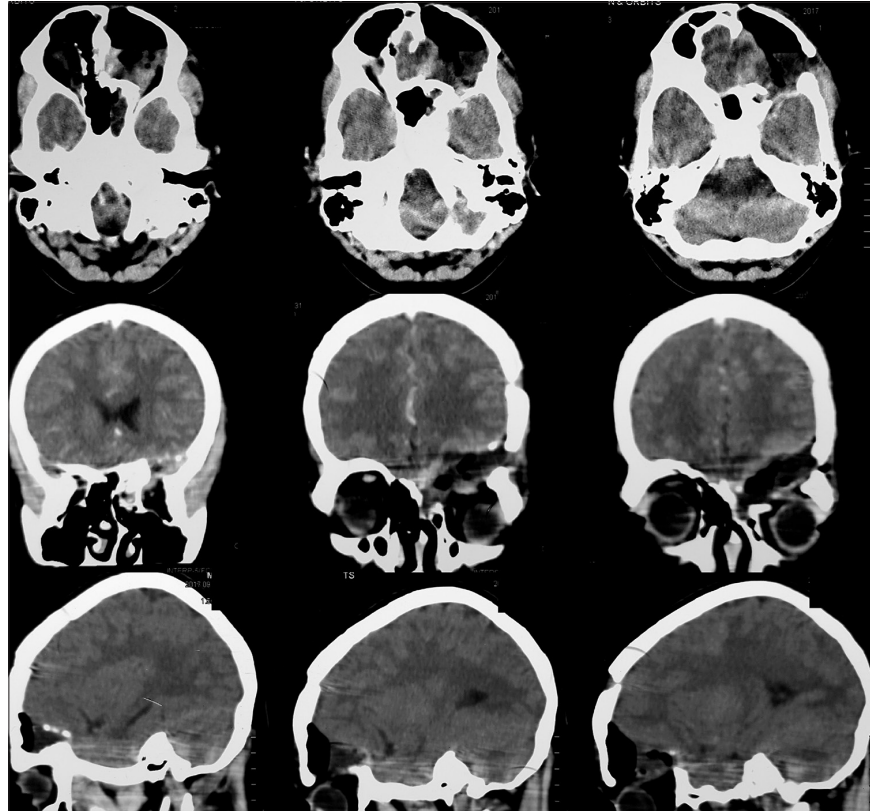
Post op CT head plain demonstrating interval resection of the lesion as well as the roof and medial wall of the orbit.
